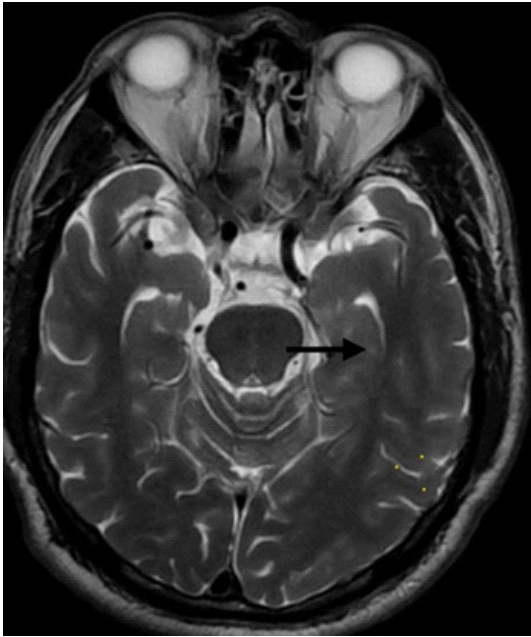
MRI brain axial T2 weighted image showing subtle hyperintensity left hippocampus (black arrow).
